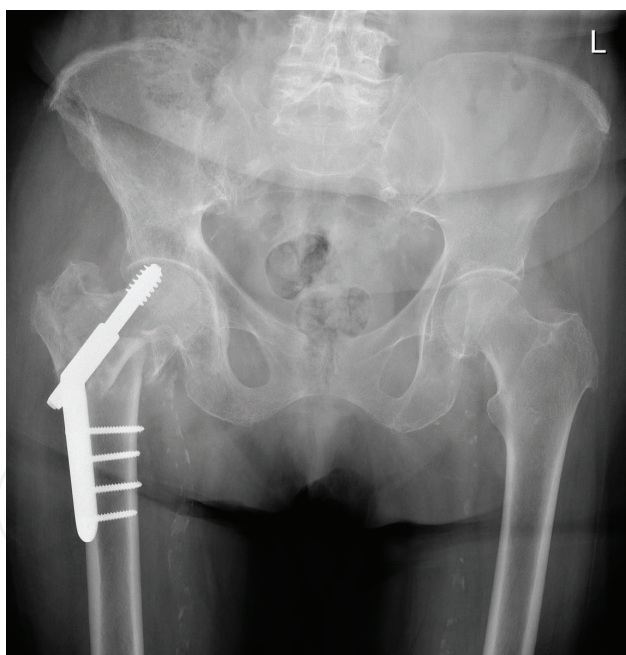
AP radiograph of pelvis demonstrating collapse of femoral head post dynamic hip screw fixation of basicervical neck of femur fracture.
